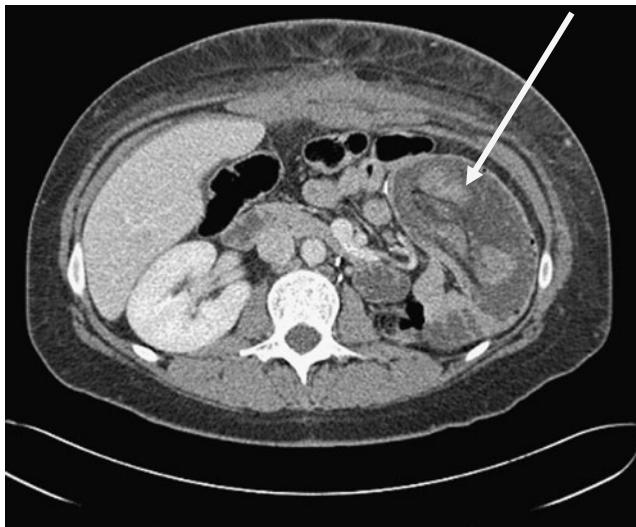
Axial view of computed tomography scan of abdomen demonstrating fluid in stomach
